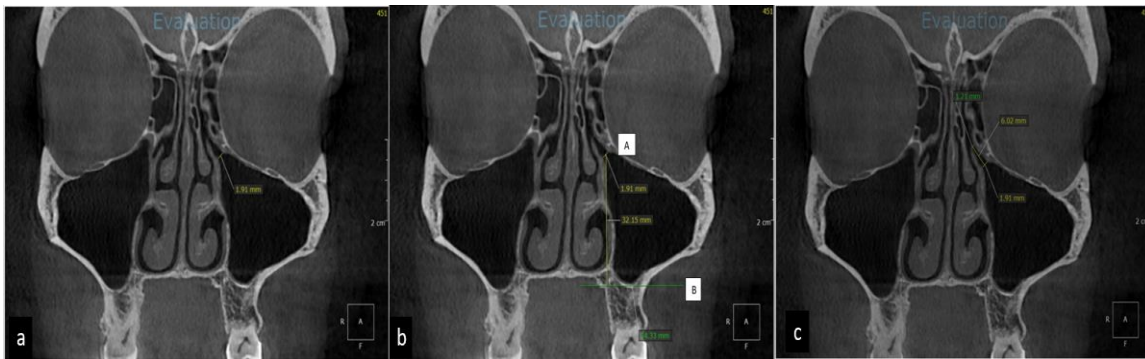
Coronal CBCT images of maxillary sinus and osteomeatal complex shows linear measurement of (a) Ostium entry size, (b) Height of ostium, (c) Length of infundibulum.
